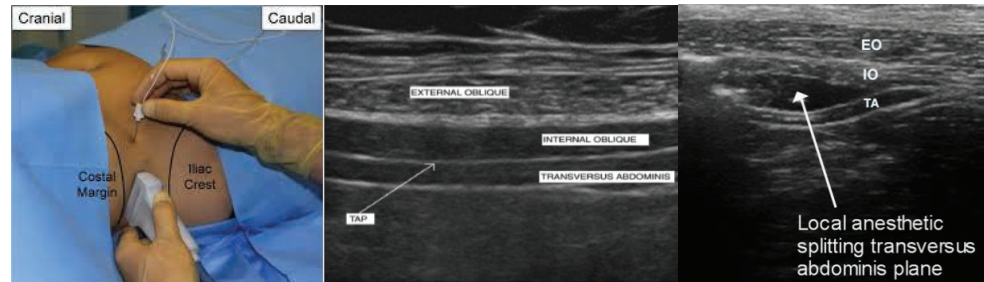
TAP block as seen via ultrasound: we can see the three muscle layers under ultrasound and spreading of the local anesthetic into the TAP between MOI and MTA.
